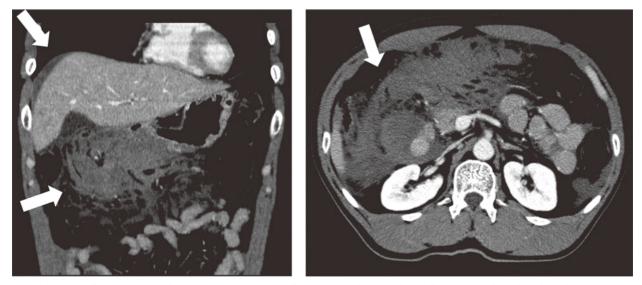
Contrasted abdominal computed tomography (CT) revealed a inflammation of right mesenteric region with fluid collection around the liver.
